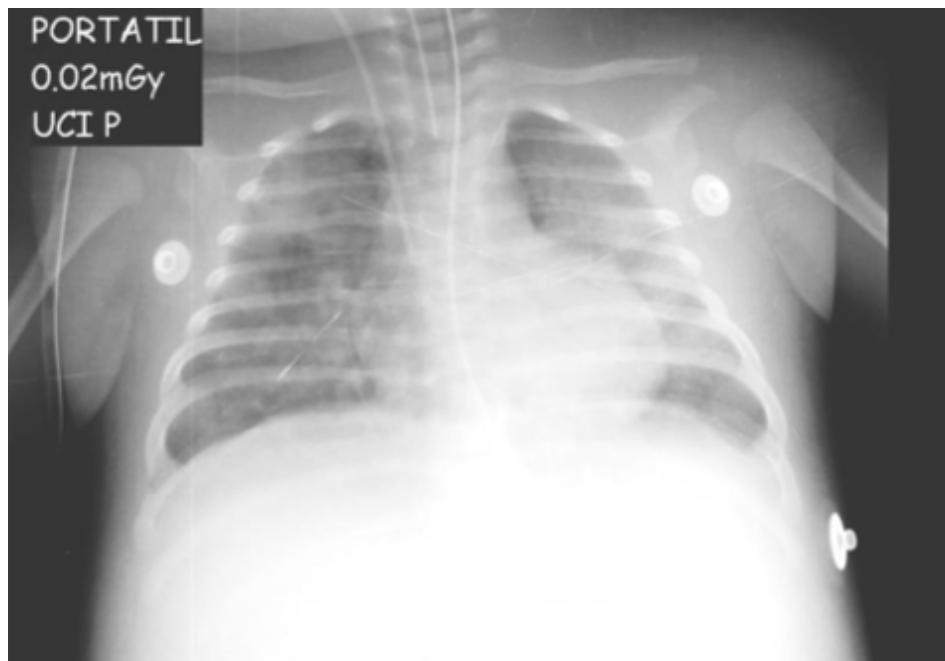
Chest x-ray: improvement in alveolar infiltrates after steroid use (2days).
